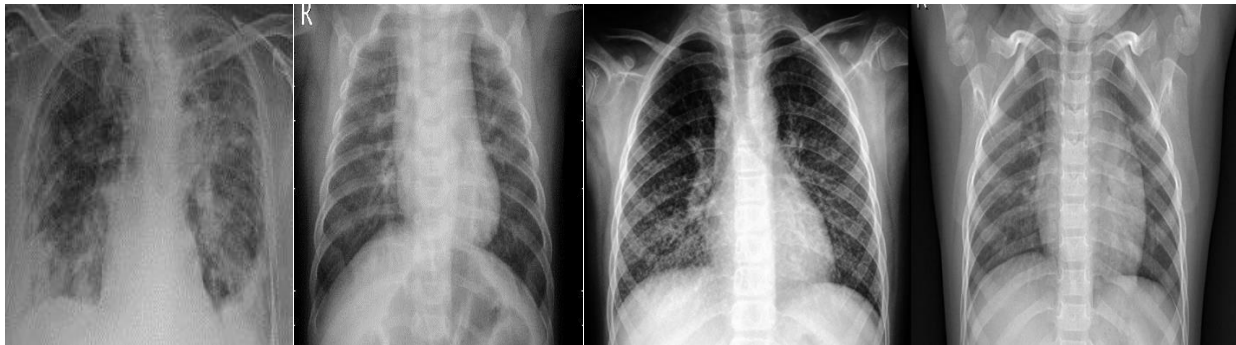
X-Ray of Covid 19
